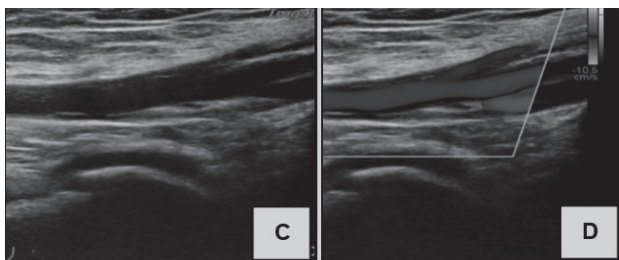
A follow-up Doppler ultrasound after 3 months; completely compressible of veins. Demonstrating resolved DVT
